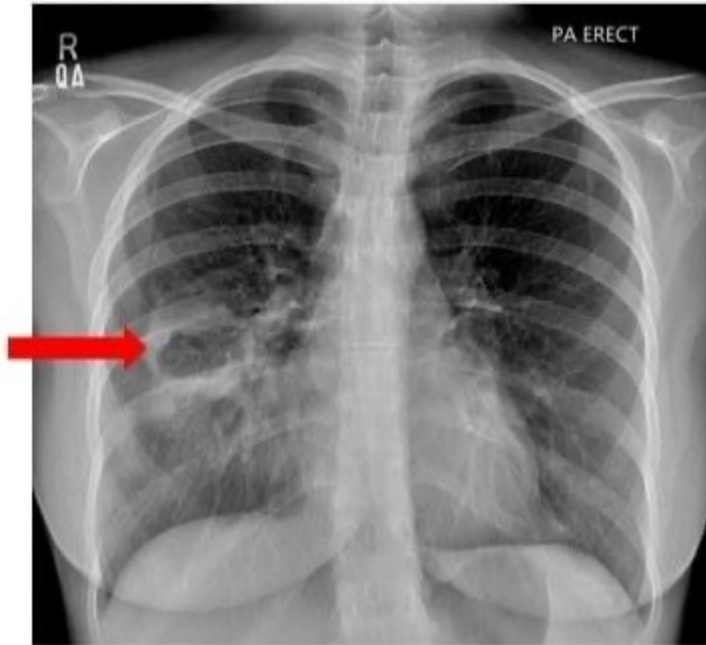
Chest radiograph showing cavity in right mid lung zone.
